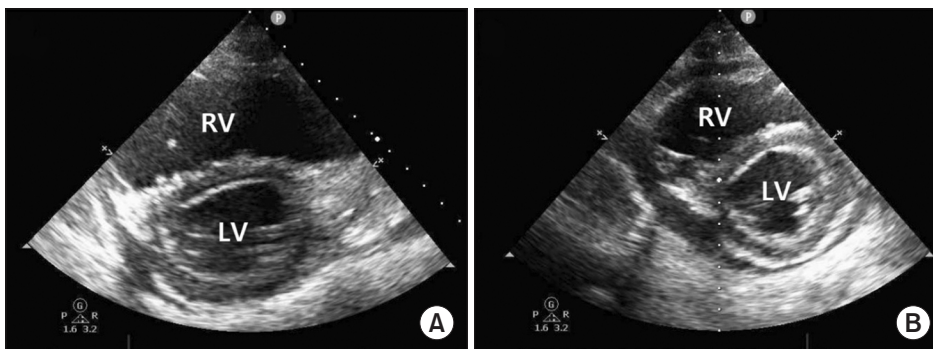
Echocardiograms demonstrating right ventricular function. (A) Before OxyRVAD insertion, showing a slightly D-shaped left ventricle (LV). (B) Day 9 after OxyRVAD insertion, showing decreased right ventricle (RV) volume.
